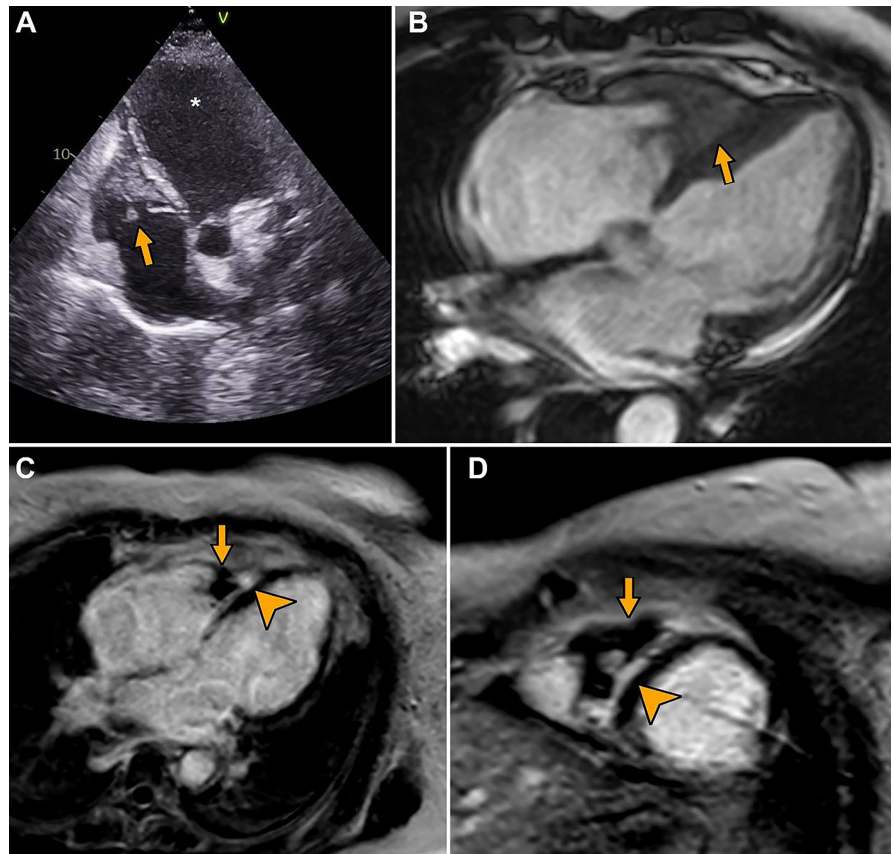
Composition of echocardiography and cardiac MRI images from our patient.
